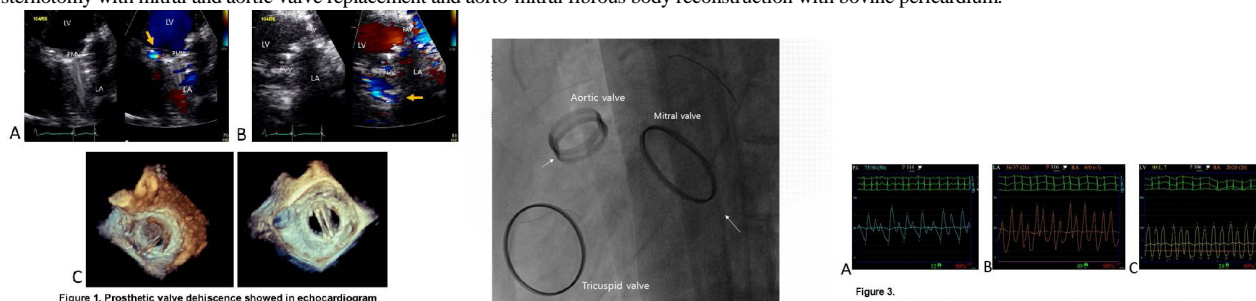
Prosthetic valve dehiscence shown in echocardiogram (A) Prosthetic valve dehiscence showed at posteromedial site of mitral valve in apical 4 chamber view of transthoracic echocardiogram. (B) Also, dehiscence showed at lateral site of mitral valve in parasternal long axis view. (C) 3D reconstruct image in trans-esophageal echocardiogram. Dehiscence site marked with white arrow.
